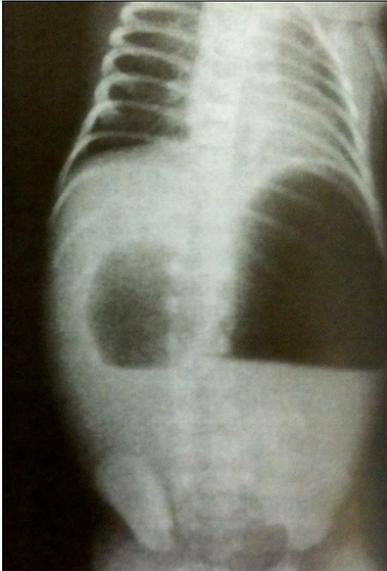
Abdominal radiograph. Data from Puri P, Höllwarth M. *Pediatric surgery: Diagnosis and management*. Berlin: Springer; 2009. p. 386
